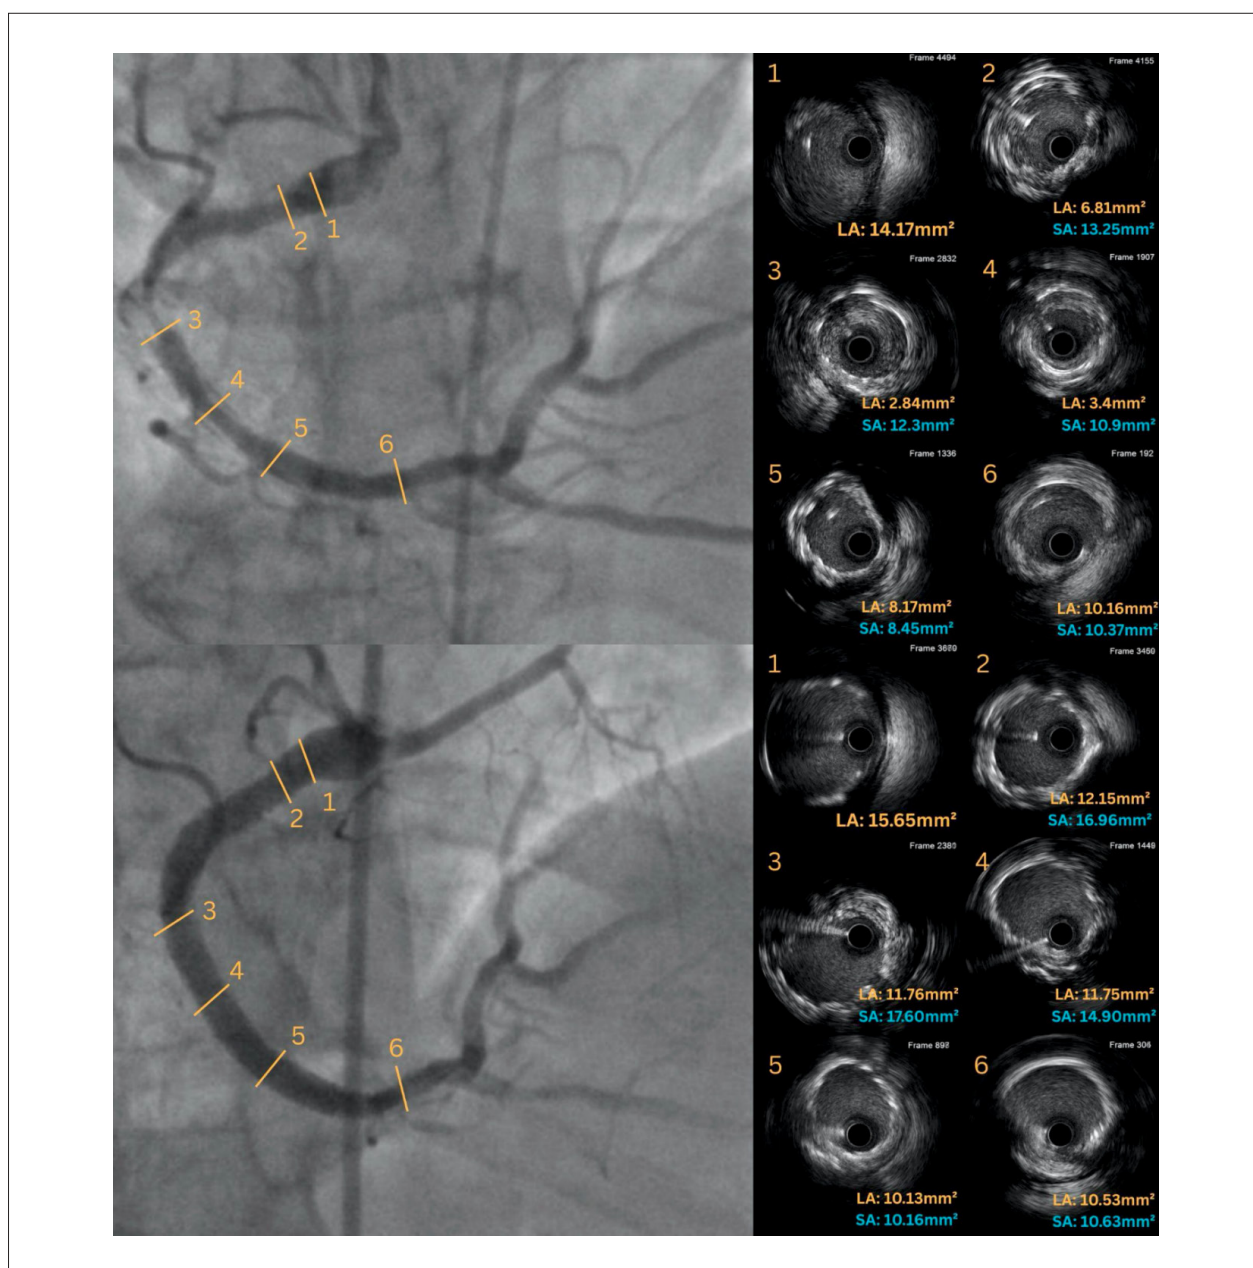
Intravascular ultrasound of the right coronary artery. Pre-angioplasty: stent with underexpansion of its struts. Post-angioplasty: implantation of one drug-eluting stent (4.0 × 38 mm) in the mid right coronary artery and one drug-eluting stent (4.0 × 33 mm) in the proximal right coronary artery, with overlap and adequate strut expansion.
